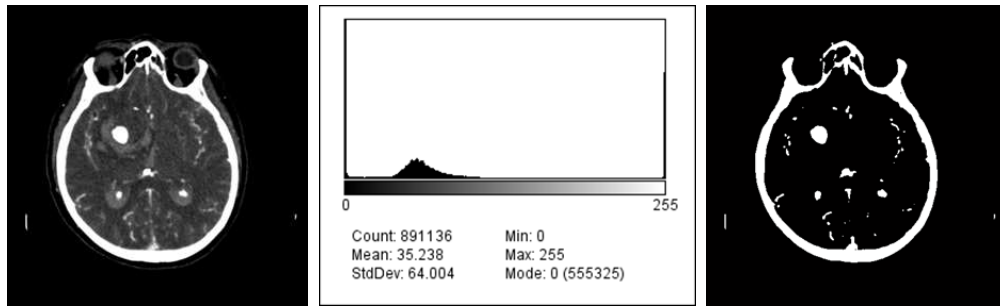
In left: original cerebral CTA image; in middle: image histogram; in right: result of thresholding method segmentation.
